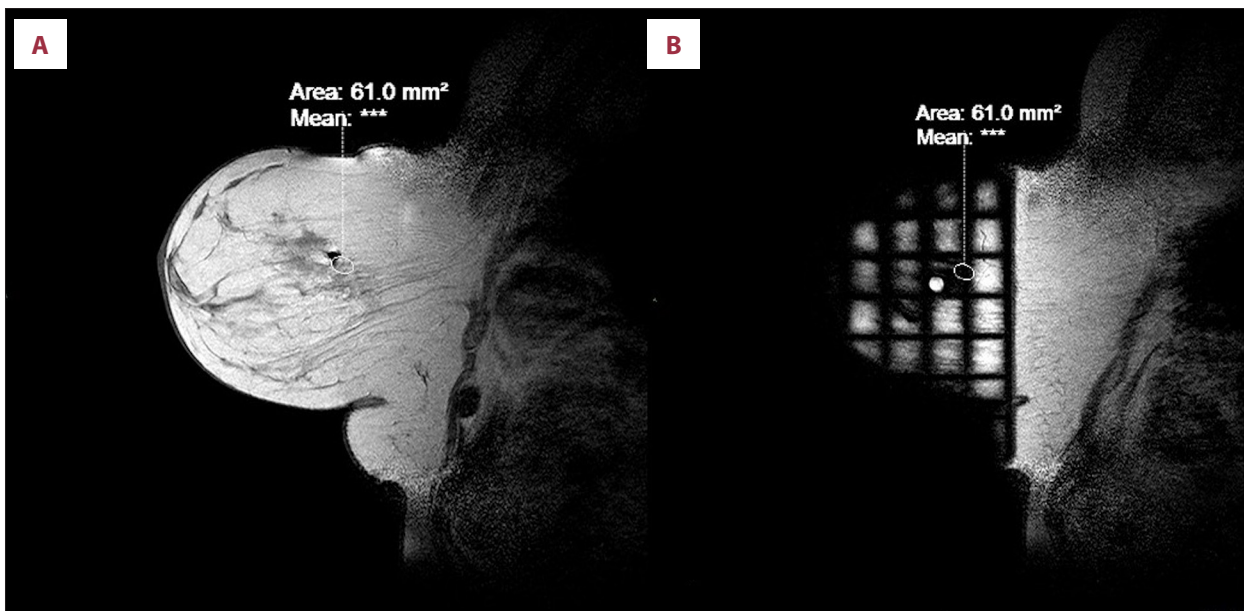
Preliminary steps of the magnetic resonance imaging-guided vacuum-assisted breast biopsy: (A) coordinates for needle placement based on the spatial relationship between the lesion, fiducial marker (solid white circle) and grid lines (B) considering slice thickness.
